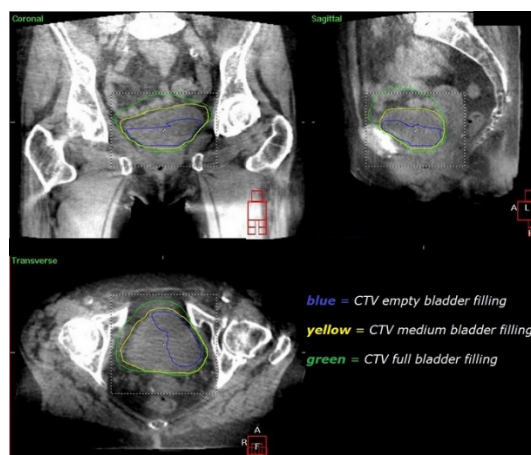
CBCT image of the initial plan. CTV medium bladder filling fits well on CBCT bladder.
